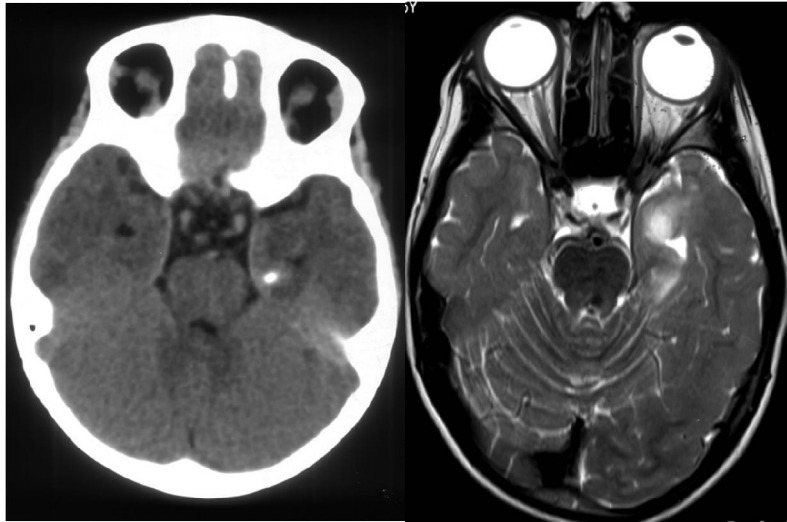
Ganglioglioma of medial temporal lobe showing calcification in axial CT brain with combination of solid cystic cortical subcortical mass in T2 MRI
